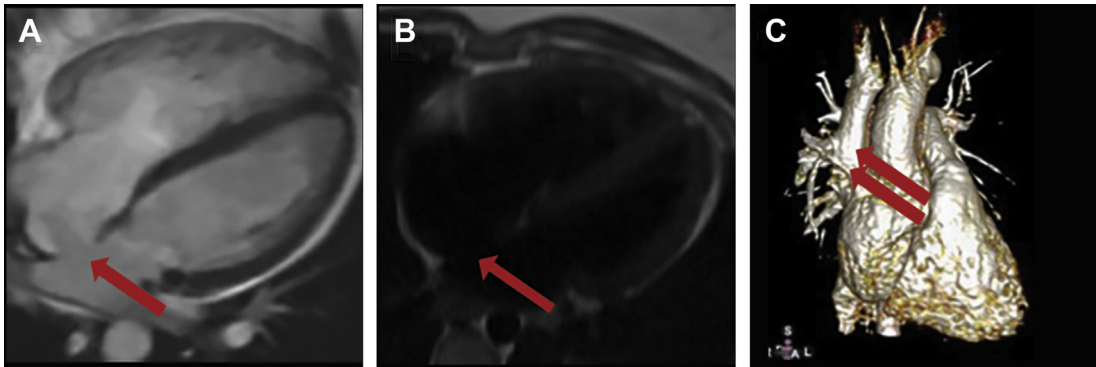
Cardiac MRI evaluation for ASDs. Routine cardiac MRI sequences used to define the atrial septum on bright blood images (gradient echo sequences) (A) and dark blood images (fast spin echo sequences) (B). These images allow definition of atrial septal anatomy (red arrow, secundum ASD), atrial and ventricular morphology and are used to assess volumetric data and to quantify ventricular function. High spatial resolution MR angiography with 3-dimensional volume rendered imaging is used to define cardiac anatomy and morphology of the great vessels and systemic and/or pulmonary veins (C). The double red arrows demonstrate anomalous return of right-sided pulmonary veins to the superior vena cava.
